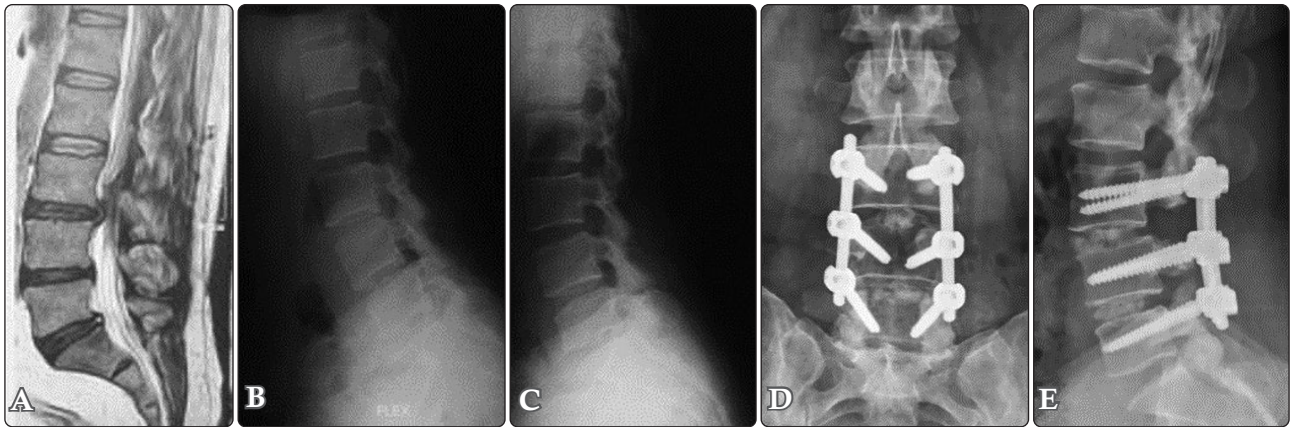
Images of a 47-year-old female patient, non-smoker, low vitamin D, ODI= 54, VAS= 6. (A) Sagittal T2 MRI showing degenerative disc changes at L3-L4, L4-L5 levels, and, to a lesser extent, L5-S1, with annular disc bulge and segmental canal stenosis at L3-L4 level. (B,C) Dynamic study showing minimal slip at L4/L5 segment. (D,E) Anteroposterior and lateral plain radiographs 6 months postoperatively, showing sound radiological fusion. Bone graft is seen well traversing the interbody space in both operated levels, yet the graft is not fully integrated with the vertebral bodies (Bridwell's grade 2).
